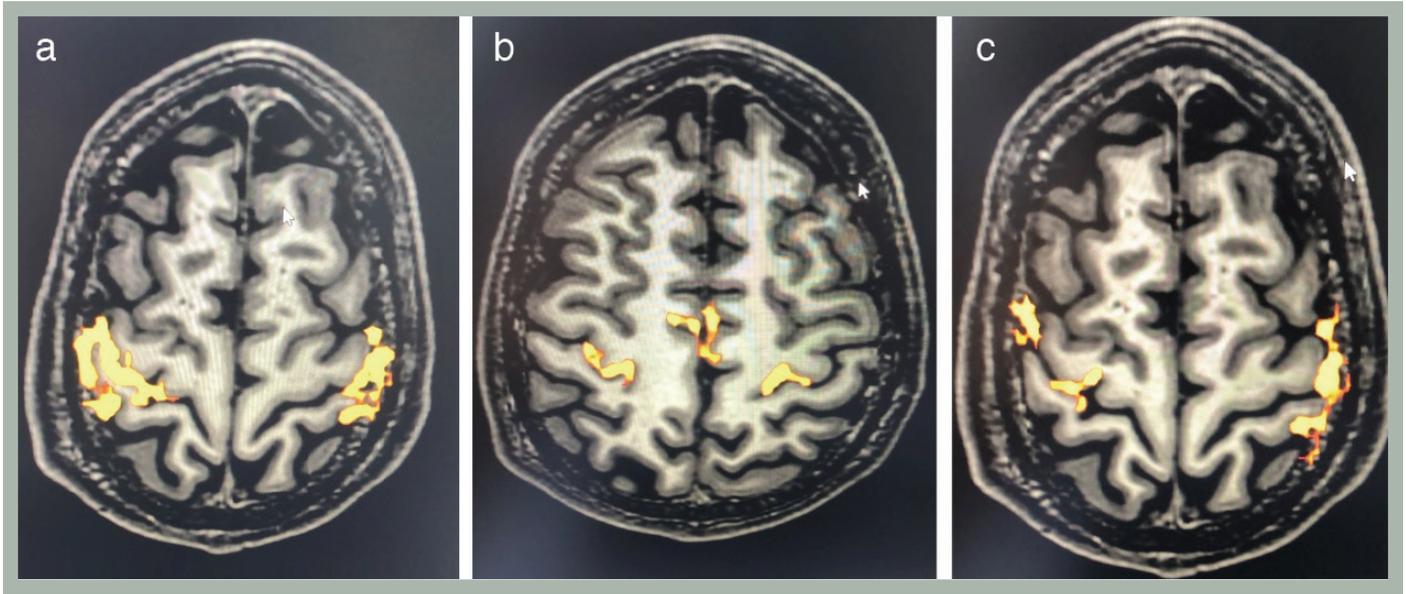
(a-c) In functional magnetic resonance imaging, it was seen that contralateral cortical motor areas were activated when both, hand actively moved and the other hand contracted involuntarily
